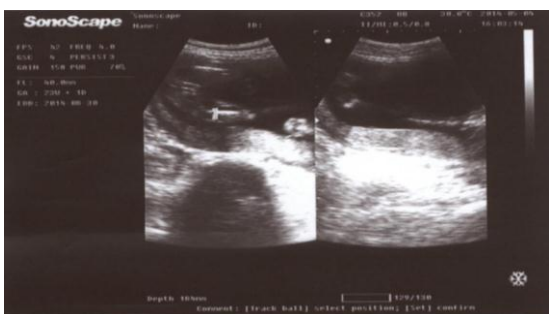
Sonogram of female fetus and posterior placenta at 29wks
